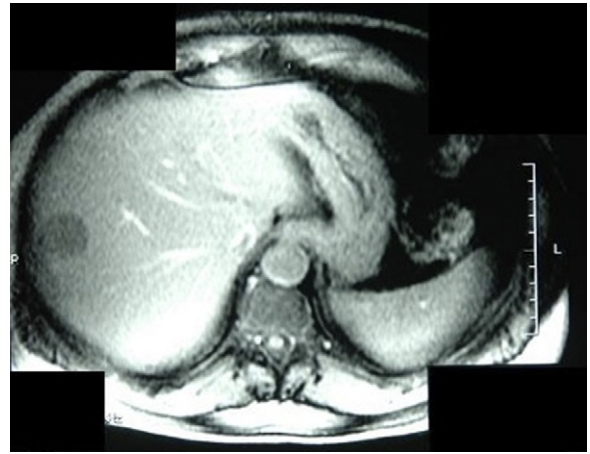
A contrast MRI of the abdomen revealed a 2.9 cm round lesion in segment VIII of the liver, with cystic/necrotic appearance.
